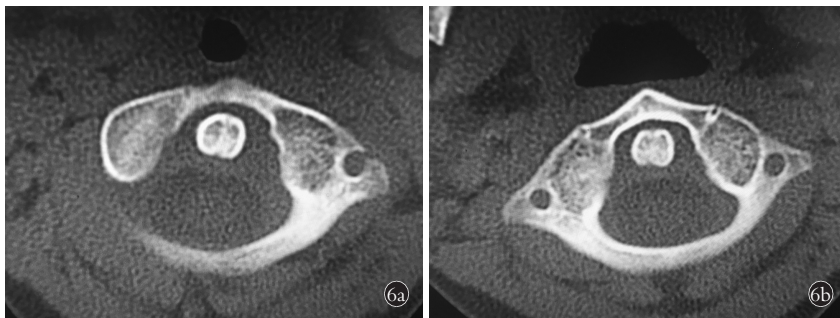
女性患者,25 岁,外伤致寰枢椎关节半脱位 6a. 治疗前 CT 示寰枢椎间隙不对称,右侧约 3 mm,左侧约 7 mm 6b. 经过 2 个月的牵引治疗后复查 CT 示寰枢椎间隙左右对称,疼痛缓解,活动自如
